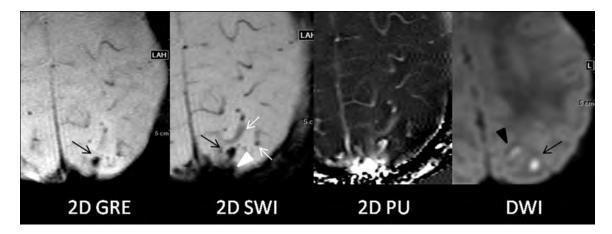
Potential pitfalls of 2D SWI/PU. Focal venous thrombosis (*black arrow*) and an adjacent area suspicious for focal venous ischemia (*black arrowhead*) on DWI are identified in a 5-month-old boy with seizures. The T2* lesion corresponding to the thrombosis is well-visualized on both 2D GRE and 2D SWI (*black arrows*) and is, in fact, even more prominent on 2D SWI images. However, prominent adjacent calvarial bony artifacts (*arrowhead*) and heightened visualization of deoxygenated and slow-flow cortical veins on 2D SWI (*white arrows*) were thought to be distracting.
